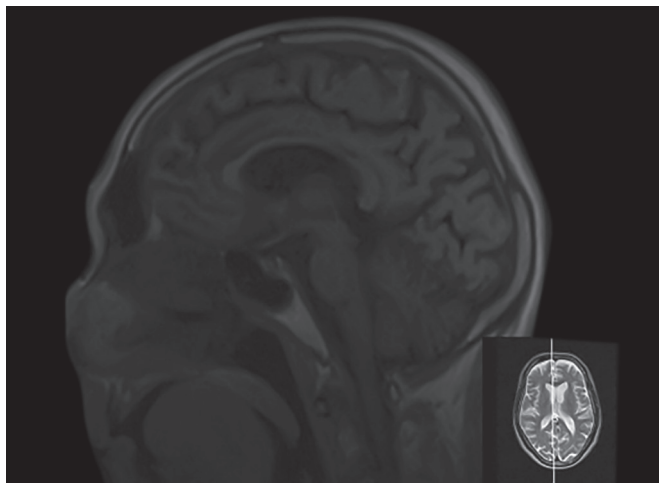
Sagittal section of MRI brain showing “hummingbird sign” (atrophy of the midbrain with relative preservation of the pons resembling the head with narrow beak and body of a hummingbird)
